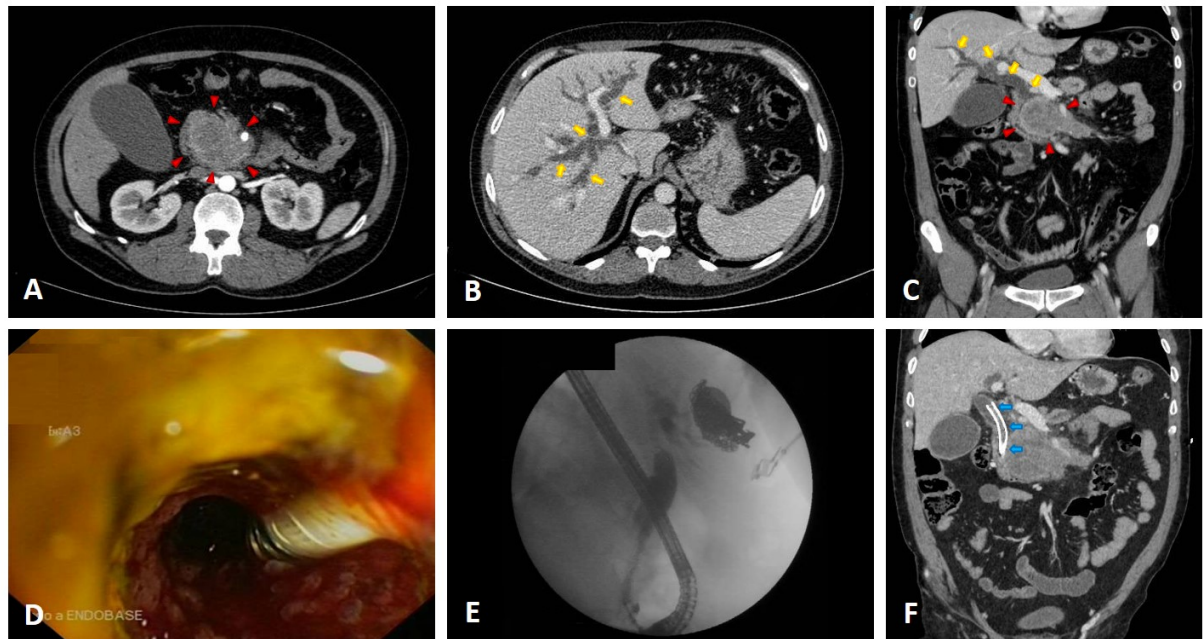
Images A, B, C (coronal): abdominal CT with lesion in the head of the pancreas (red dots) causing dilatation of the intrahepatic and extrahepatic bile ducts (yellow arrows). D, E: ERCP with self-expandable metallic stent in common bile duct, identifying a stop of contrast and a filiform passage through the stent. F: Coronal CT with progression of the pancreatic lesion and extrinsic compression of stent (blue arrows).
